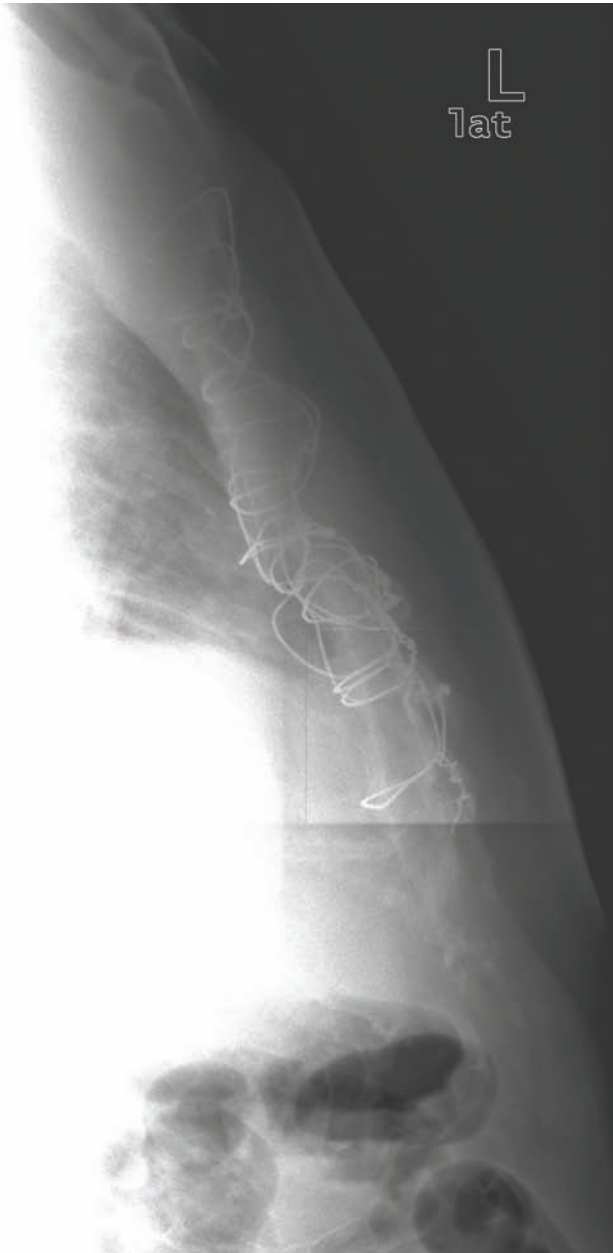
Postoperative radiograph (lateral view) of the patient in case 1.
